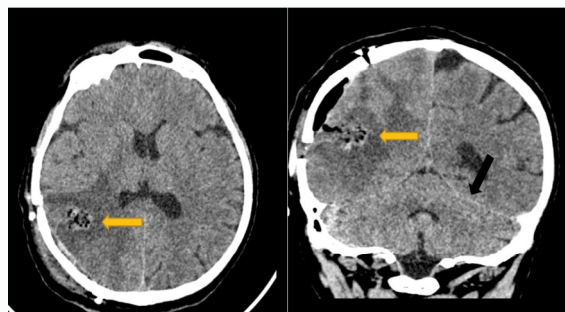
Two dimension postoperative CT scan of brain, the yellow arrows showing the post-resection cavity, black arrow points the tentorium cerebelli.
